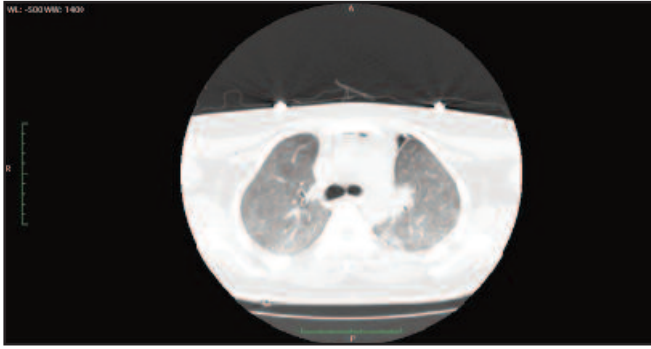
Unenhanced CT thorax, lung setting:
